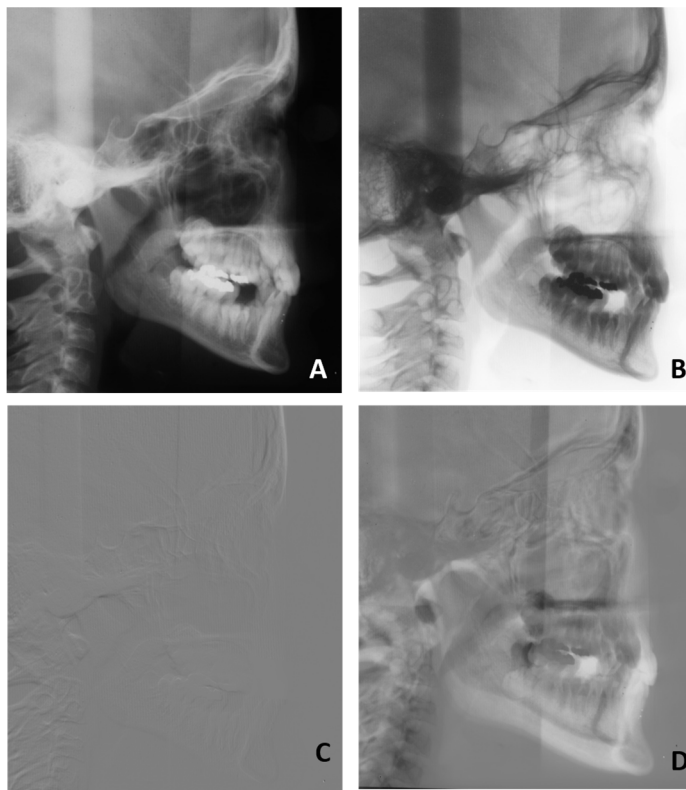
Lateral cephalograms acquired from the same patient. A) Original cephalogram at 10 years of age. B) Inverted copy of the original cephalogram. C) Superimposition of the original radiograph onto the inverted copy. Unchanged structures are extinguished in this case, resulting in a homogeneously grey image. D) Original inverted cephalogram superimposed onto a cephalogram acquired after 4 years of growth. Changes to the upper and lower jaw are visualised, whereas unchanged structures are extinguished, as in panel C.
